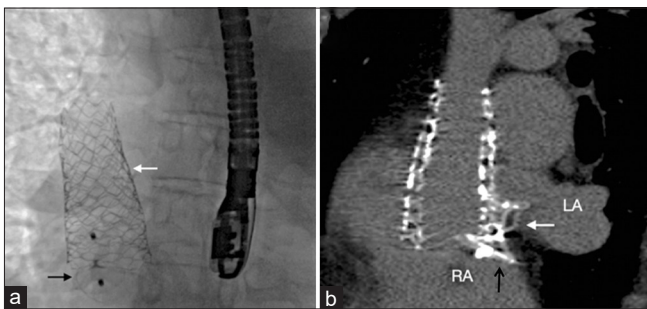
A small residual flow (a) across the edge of the stent (white arrow) that persists even after dilating the lower end with a larger balloon is closed by a Konar-MF device (black arrow). After 6 months, a computed tomographic image (b) shows the covered stent and the occluder. RA: Right atrium, LA: Left atrium
